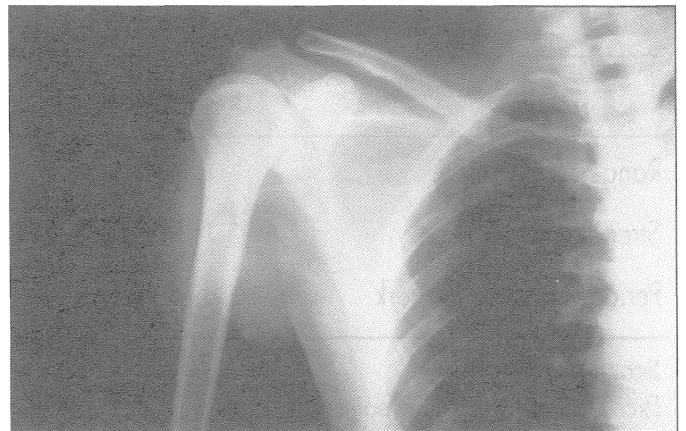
Post-operative radiograph of modified Weaver-Dunn technique
